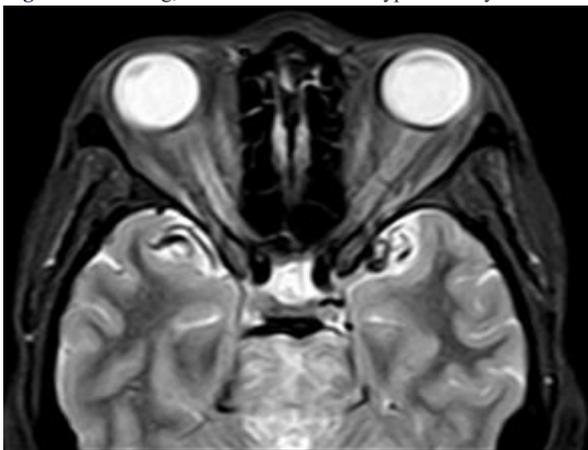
MRI showing, Axial FLAIR - Diffuse hyperintensity in Mid brain
